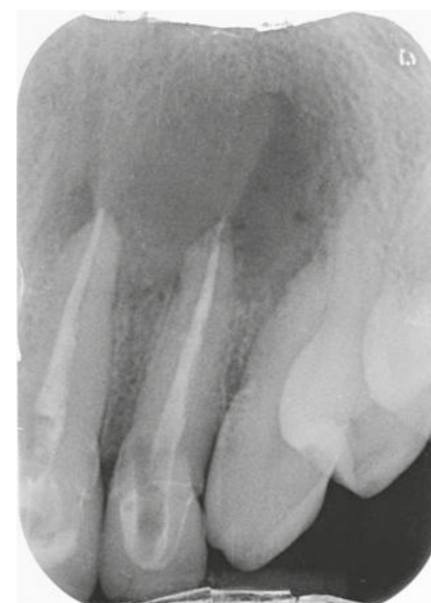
Periapical radiograph of tooth 22.
